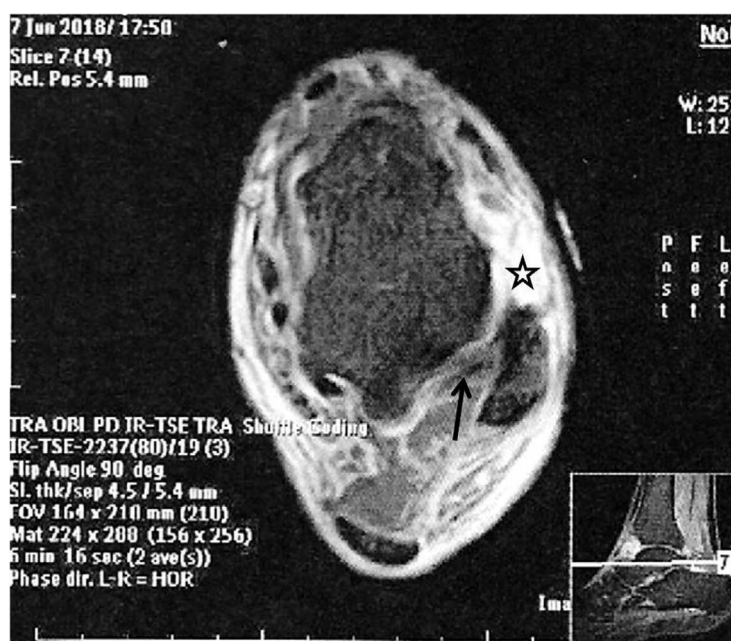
Transversal MRI. Rupture of the anterior talofibular ligament (star) with intact posterior talofibular ligament (black arrow).
